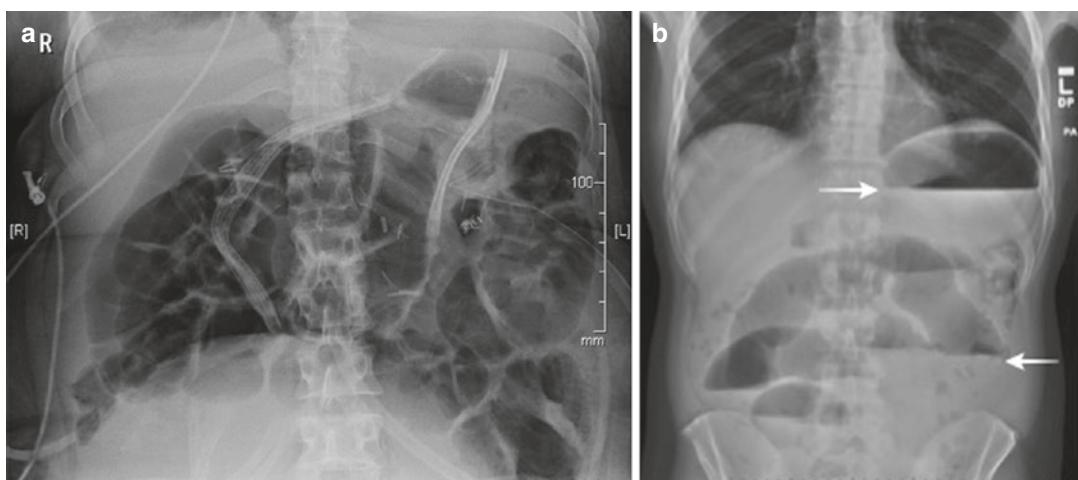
(a) Plain X-ray of a 27-week pregnant female with multiple dilated loops of small bowel secondary to adhesive small bowel disease. (b) Plain X-ray of a small bowel obstruction with multiple air fluid levels (*white arrows*)
